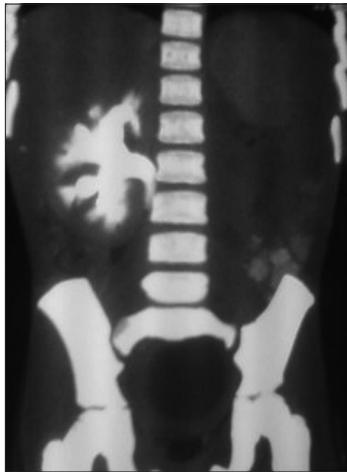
Contrast-enhanced computed tomography-right kidney showed mild hydronephrosis and hydroureter with left renal agenesis
